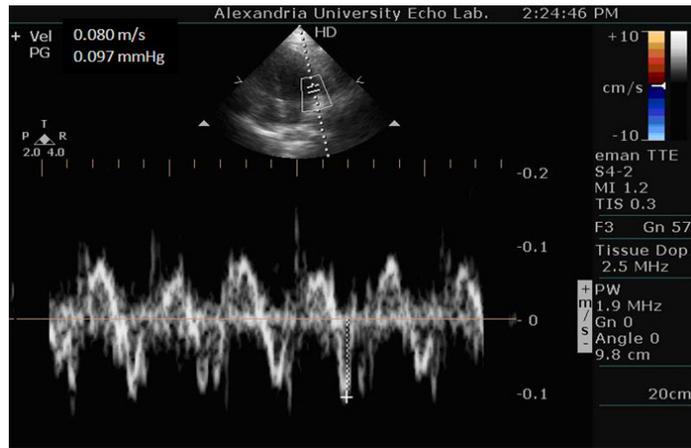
Tissue Doppler lateral mitral annular velocity before dialysis.
